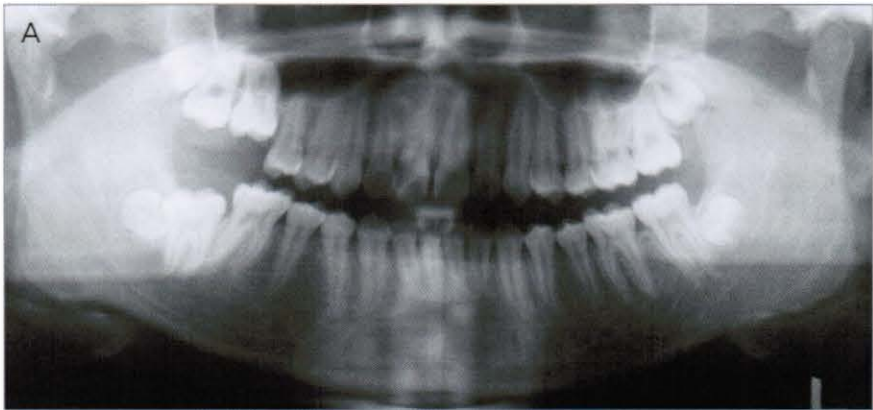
Pre-treatment and early panoramic radiograph
